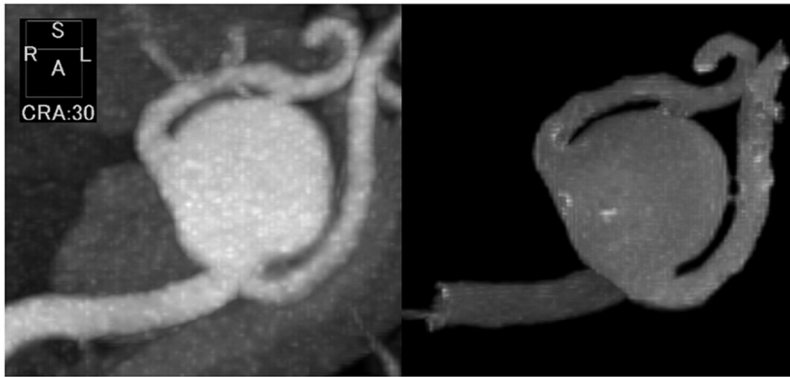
A 66-year-old man with a 2-cm splenic artery aneurysm. Maximum intensity projection (MIP) images created from the original computed tomography (CT) angiography data (left) and from T2-weighted magnetic resonance (MR) data of a 3D-printed hollow aneurysm model filled with water (right).
